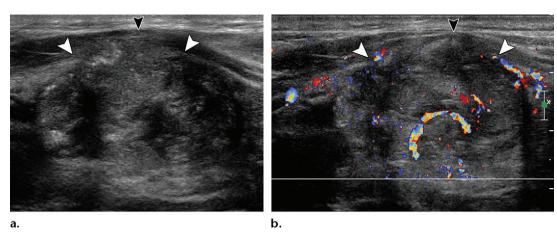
Extracapsular extension of a right papillary thyroid cancer in a 25-year-old man. (a) Gray-scale US image demonstrates a 3.8-cm heterogeneous solid nodule with indistinct anterior margins (white arrowheads) and invasion of the overlying strap muscle (black arrowhead), which was confirmed intraoperatively. (b) Color Doppler US image demonstrates central and peripheral hypervascularity with extracapsular extension (white arrowheads) and strap muscle invasion (black arrowhead).
